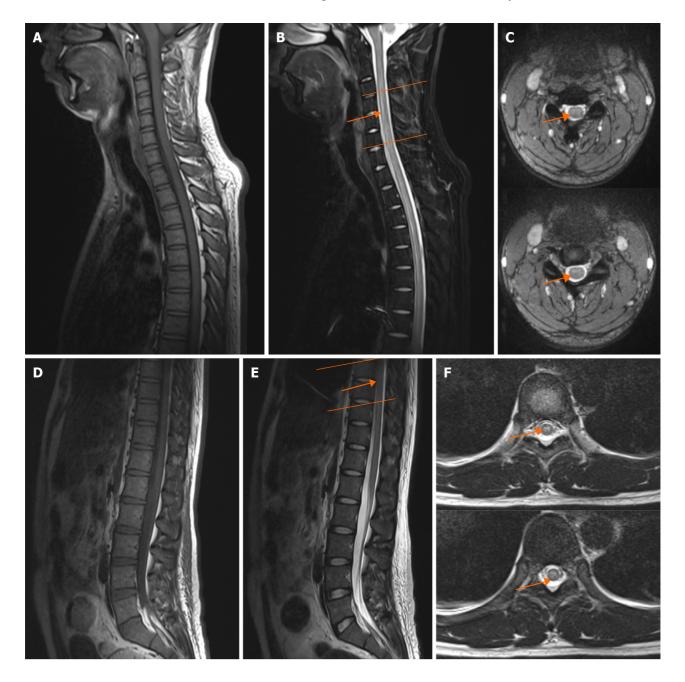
A magnetic resonance imaging scan of the thoracic spinal cord of the patient before treatment. A: Sagittal T1WI sequence of the cervical spine; B: The sagittal T2WI-FS sequence of the cervical spine shows hyperintensity in the long central segment of the spinal cord C3-C6 (arrow); C: Axial T2WI sequence of the cervical spine shows hyperintensity in the central spinal cord at the C3-C6 level (arrow); D: Sagittal T1WI sequence of the lumbar spine; E: Sagittal T2WI sequence of the lumbar spine shows hyperintensity from the central long segment of the T7-T8 spinal cord (arrow); F: Axial T2WI sequence of the lumbar spine shows hyperintensity at the T7-T8 level (arrow).
